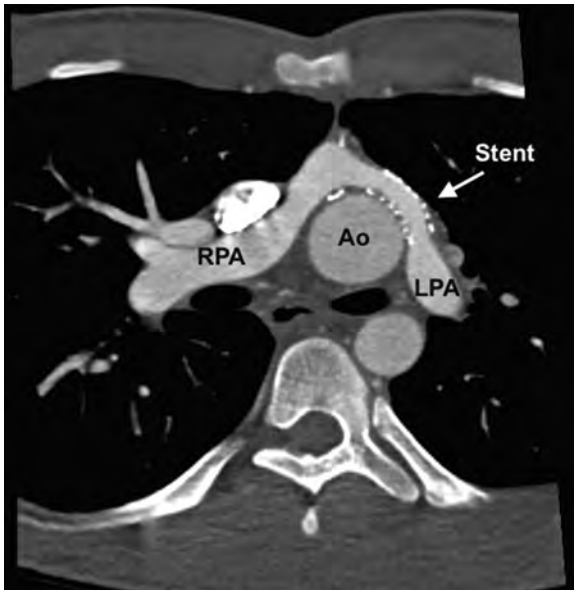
Axial 2D computed tomographic images of a stent in the proximal left pulmonary artery (LPA) after the LeCompte maneuver performed as part of the ASO. Ao, Aorta; RPA, right pulmonary artery.
